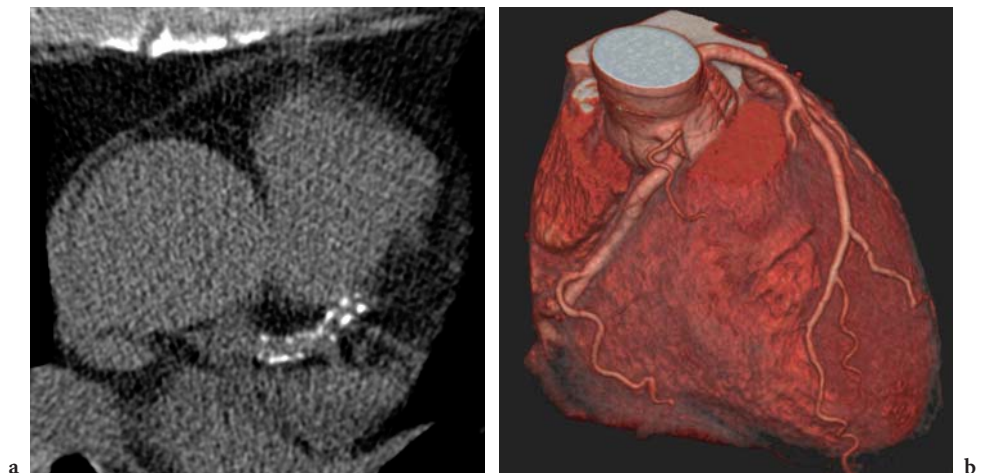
16-slice CT examination of a patient with chest pain. a A non-contrast scan is performed prior to the contrast-enhanced study to evaluate the amount of calcification. b The contrast-enhanced study demonstrates no hemodynamically relevant stenosis, and no coronary catheterization was recommended
